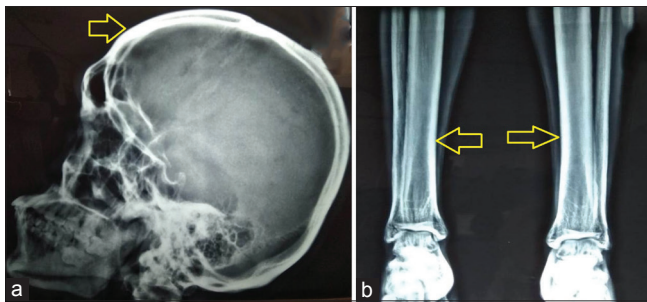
Radiograph of the skull (a) and both legs showing cortical thickening (b)
